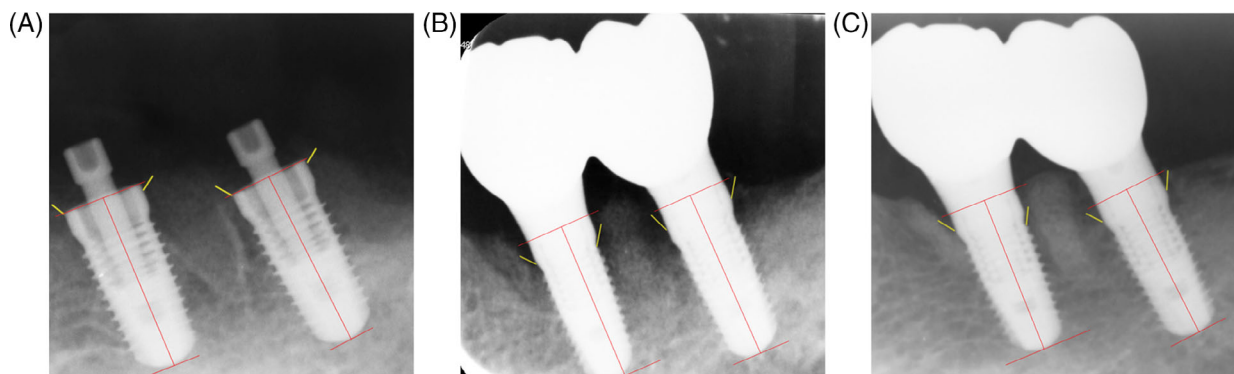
Periapical x-ray. Yellow short lines indicate the mesio and distal marginal bone levels. The red line section between the coronal and apical horizontal lines indicates the length of the implant, which was used as calibration for marginal bone resorption measurement. A, Immediate loading after surgery. Note the radiolucency of the PMMA bridge. B, Final restoration delivery after 4 months of healing. C, One-year follow-up
